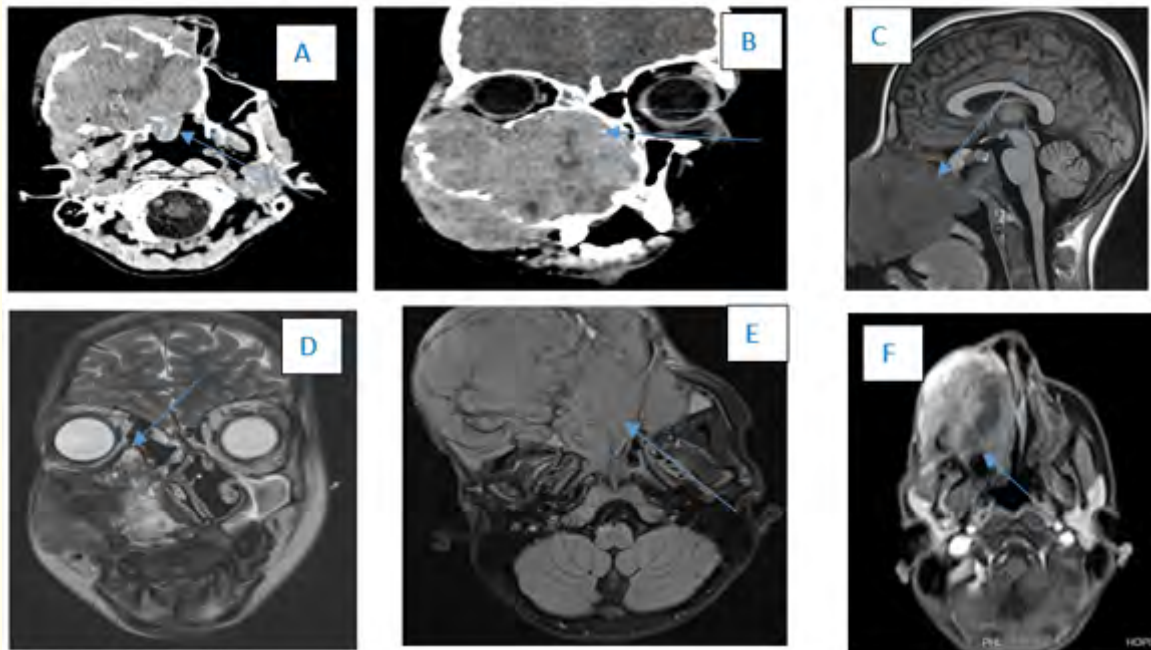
Cerebral CT scan without and with injection (A-B) with cerebral MRI in sagittal T1 ©, coronal T2 (D), axial FLAIR (E) and T1 injected section (F) showing a tissue process of the right maxillary sinus in hyposignal T1 and intermediary signal T2, heterogeneously enhanced infiltrating the homolateral zygomatic bone, infiltrating the orbital floor with exophthalmos, infiltrating the choanae and bulging into the lumen of the rhinopharynx and nasal cavities and the homolateral ethmoidal cell, thus infiltrating the maxillary bone and extending to the homo and contralateral dental arch with lysis of the roots of the upper teeth bilaterally, without calcification or hemorrhagic areas.
